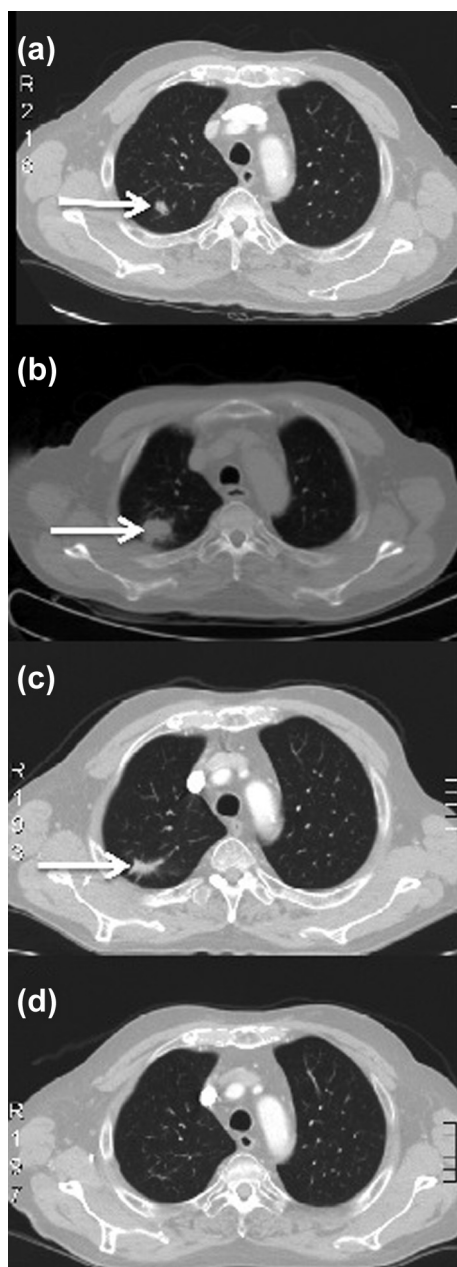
(a) Computed tomography (CT) scan of the thorax at presentation showing a cavitating lesion in the right upper lobe of the lung measuring 15 × 9 mm. (b) positron emission tomography (PET)/CT scan showing progression after 2 weeks to 20 × 26 mm. (c) PET/CT scan showing regression of lesion to 14 × 18 mm. (d) CT scan showing near complete resolution after 7 months of follow up.
